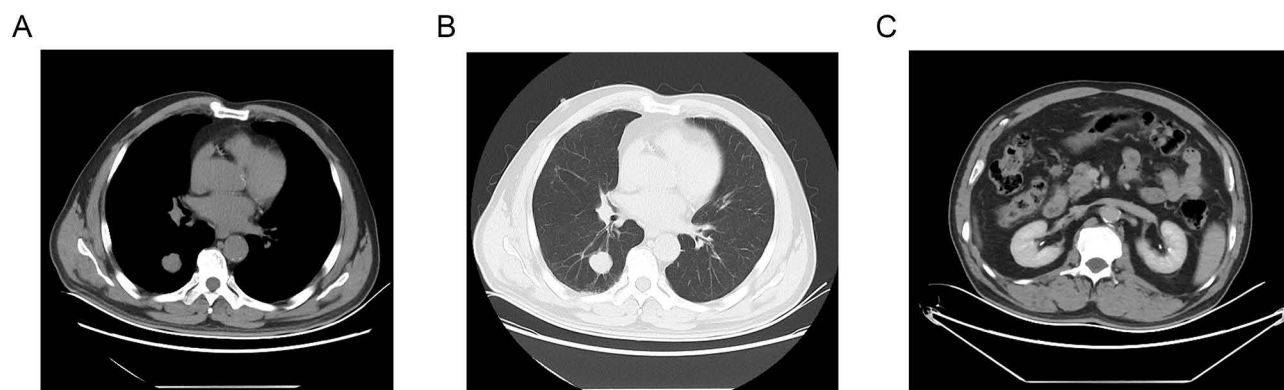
Chest and abdominal CT scan results prior to the patient entering the maintenance therapy phase (May 25, 2023). (A) The patient's chest CT mediastinal window reveals multiple solid nodules in both lungs. The largest nodule is located in the right lower lobe and remains stable compared to previous findings (2.5 \times 2.4 cm). (B) Patient's chest CT image in lung window. (C) Abdominal CT reveals thickening of the greater curvature wall and gastric fundus, with perigastric lymph nodes showing reduced size compared to previous imaging (1.4 \times 1.5 cm).
